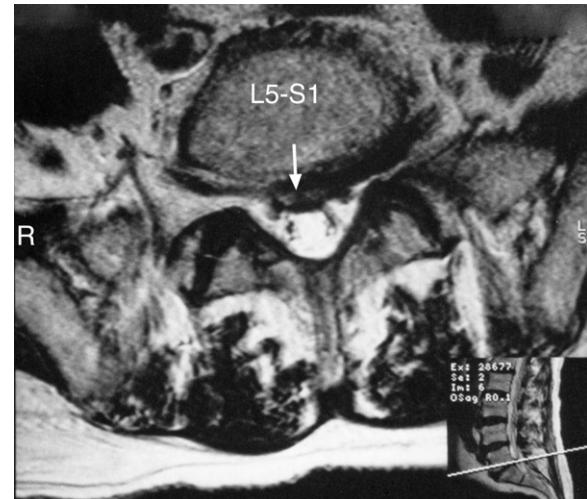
MRI axial T2-weighted image at the L5–S1 level showing a moderate posterior disc protrusion (arrow) without neural compression. Minor zygapophysial facet joint degenerative change is present bilaterally.
